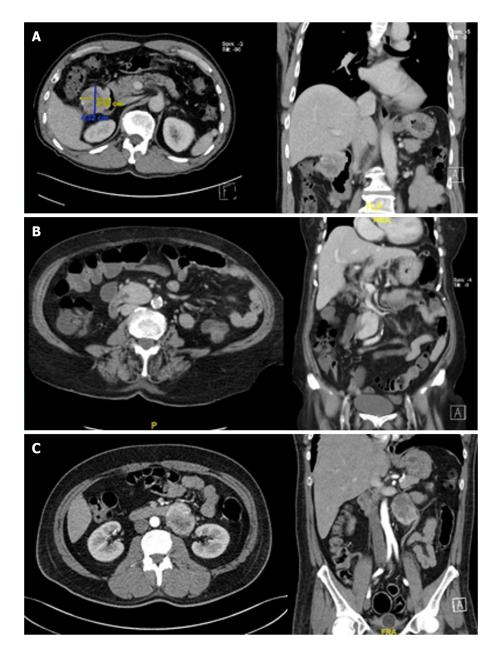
Computed tomography scan images of duodenal gastrointestinal stromal tumor in axial and coronal view. A: A 4.58 cm × 4.32 cm heterogeneous enhancing mass located at the anti-mesenteric border of the second part of the duodenum; B: A 3.4 cm × 2.9 cm homogeneous enhancing lobulated soft tissue involving the third part of the duodenum showing both intra- and extraluminal component; C: An enhancing mixed density partly necrotic mass measuring 4.7 cm × 6.6 cm arising from the fourth part of the duodenum with a large exophytic component posteriorly.
